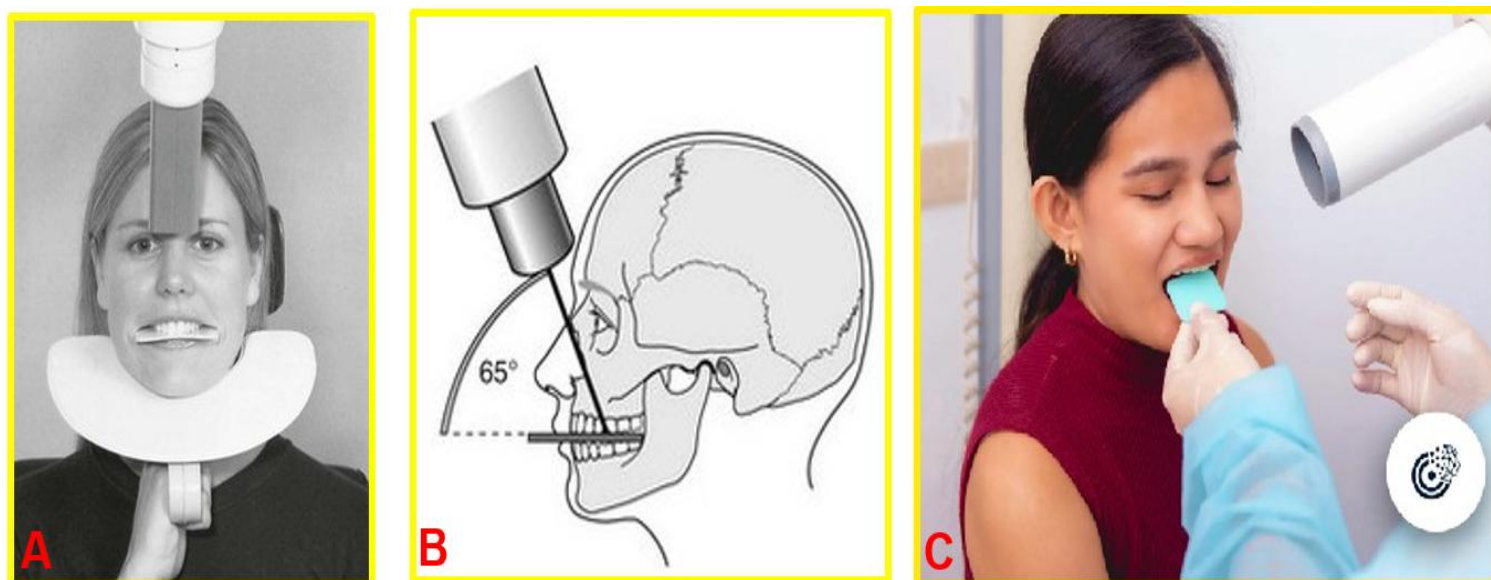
Maxillary occlusal projection of occlusal radiograph (A-C).
